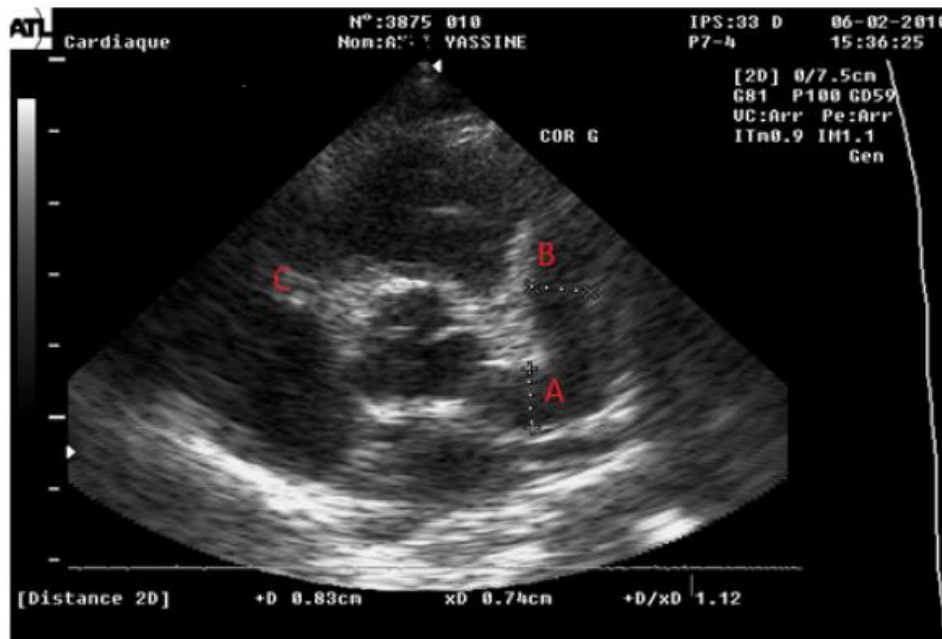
Echocardiography of 5 months-old child, showing a 9.3 mm aneurysm of the left coronary artery (A), Anterior interventricular, 8.2 mm (B) right coronary artery, de 6.2 mm (C). (Photo: Pediatrics Service 4, Rabat Children’s Hospital)
